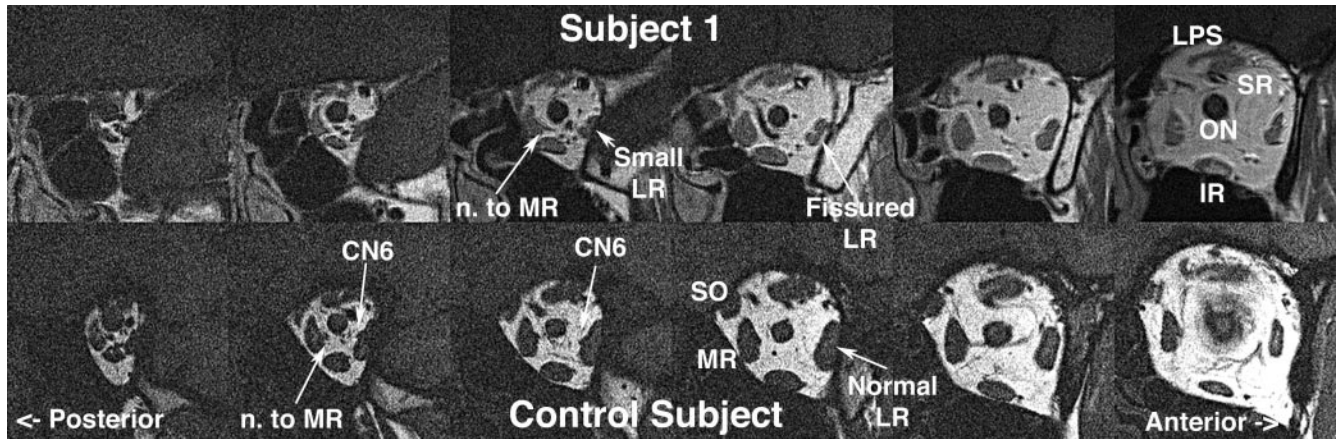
Coronal MRI of left orbit in planes 2-mm thick spaced by 2 mm, resolution 234 μm in plane. *Top row:* subject 1 with clinical phenotype of DRS unilateral type 3 on the right only. Note hypoplasia of the deep portion of the LR, without a recognizable abducens nerve (CN6). The LR is also fissured. Also evident is the motor nerve to the MR. *Bottom row:* normal control subject, showing a normal LR cross section.
